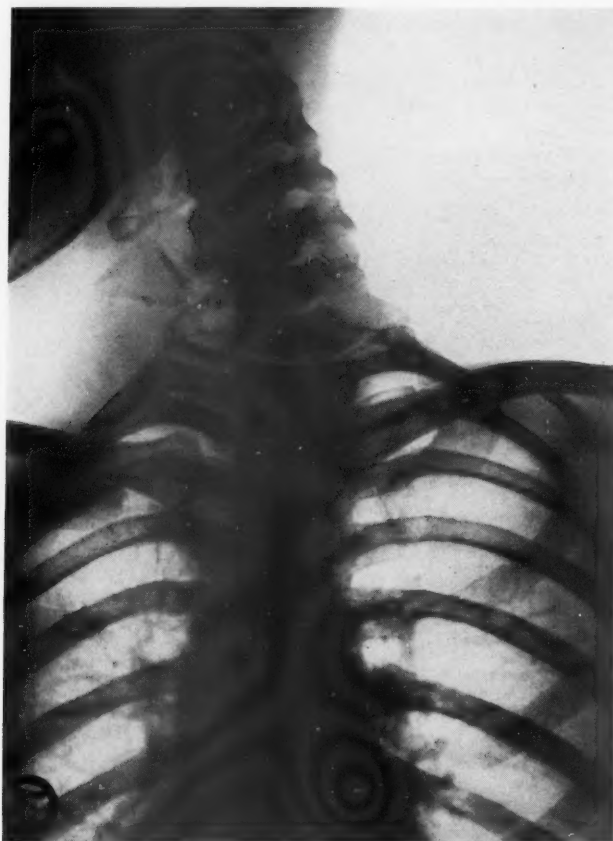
Preoperative roentgenogram of Case I. The cervical rib is shown as a direct shadow running from the seventh cervical transverse process down to and articulating with the rib just above the shadow of the clavicle.
